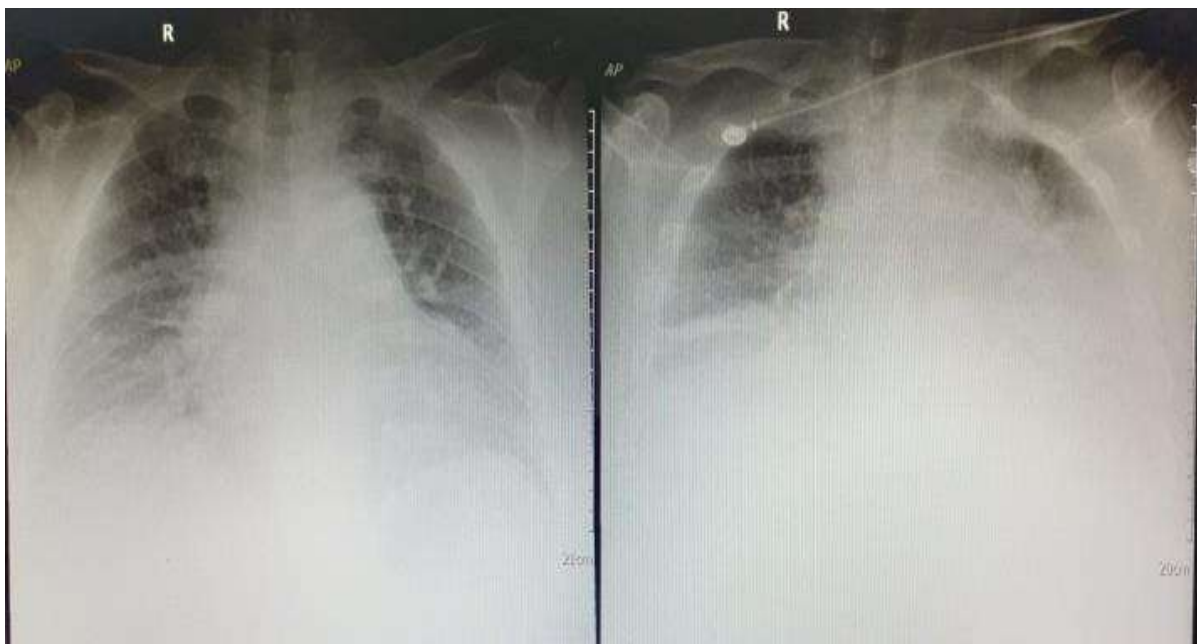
Left. Chest X-Ray: Cardiomegaly with pulmonary vascular congestion and interstitial pulmonary edema; Right. Chest X-Ray 6 days later: Increased lung opacity (worsening)
